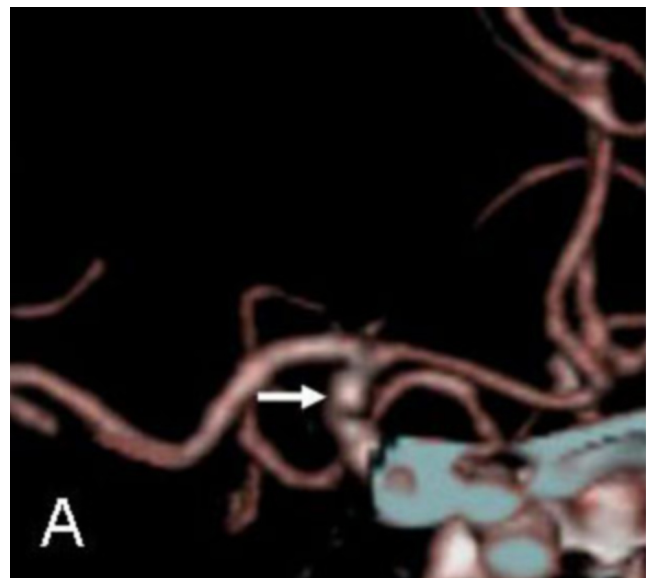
63-year-old female with anterior-wall aneurysm of the ICA. 3D CTA delineates a tiny bulge (“blood blister-like” aneurysm) on the surface of the anterior wall of the distal right ICA (arrow).
